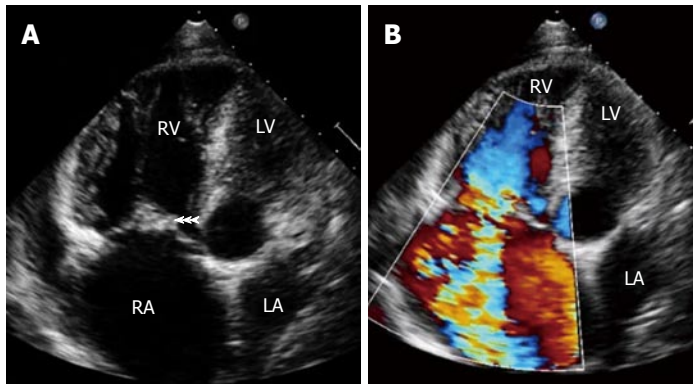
Transthoracic echocardiography showing (A) large vegetation attached to tricuspid valve leaflets (arrowheads) in a patient with intravenous drug abuse and septic pulmonary emboli. Note hugely dilated right atrium and right ventricle and (B) severe tricuspid regurgitation. RA: Right atrium; RV: Right ventricle; LA: Left atrium; LV: Left ventricle.
